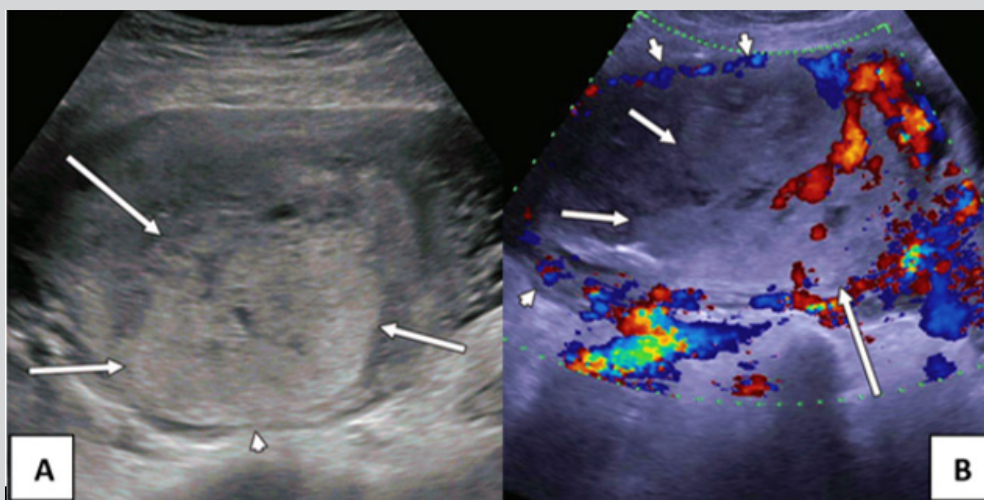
Choriocarcinoma. A. Transabdominal ultrasound showing a large hyperechogenic uterine mass (long arrows) invading the posterior myometrium (short arrow) reaching the serosal surface. B. Transabdominal Doppler imaging with a large, heterogeneous, predominantly hyperechoic vascular mass (long arrows) surrounded by highly vascularized myometrium (short arrows).
